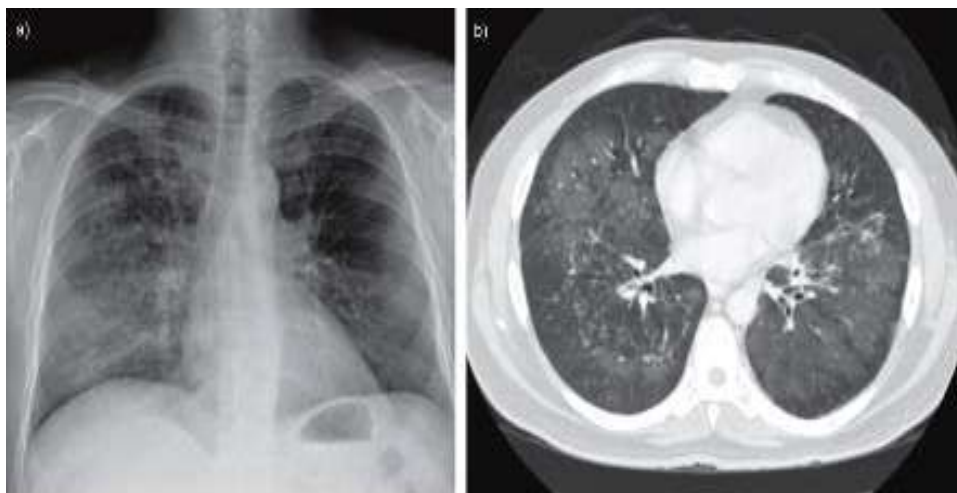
Chest X-ray and CT scan of pulmonary pneumocystis : Diffuse bilateral infiltrative opacities without cavitation.
